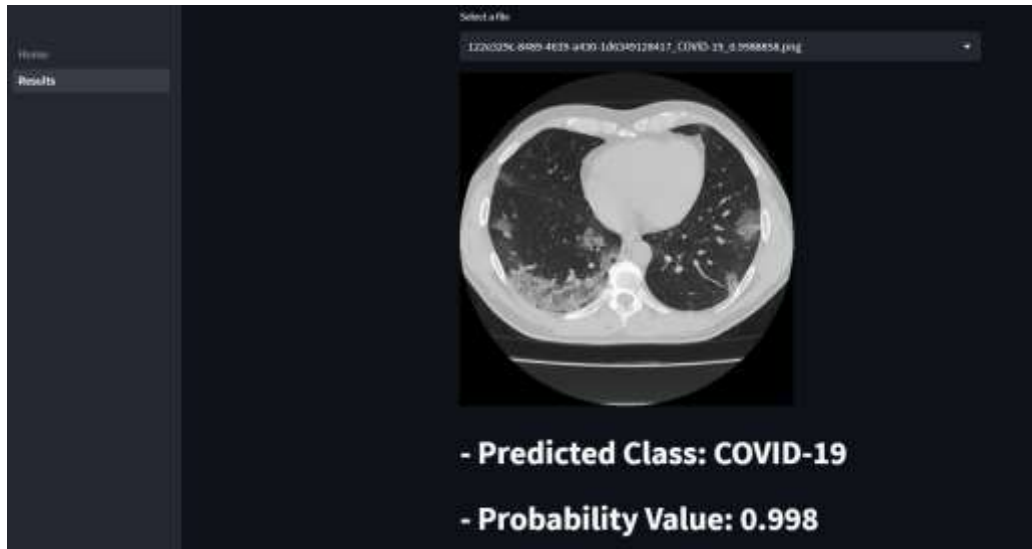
COVLIAS 3.0_{XEDL} Cloud App showing a COVID-19 CT scan.
